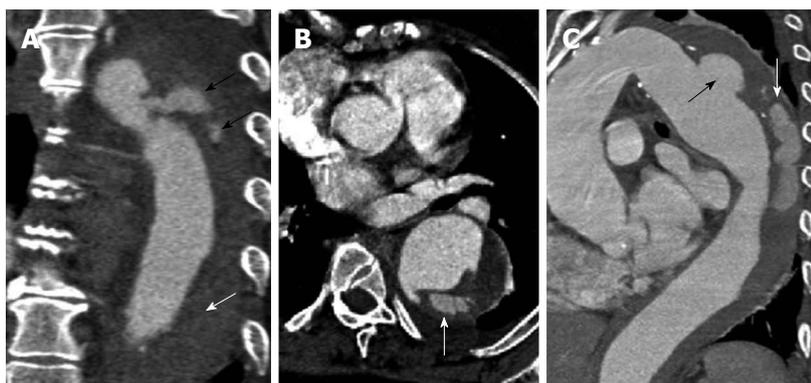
A 62-year-old with acute chest pain. A computed tomography aortogram (A-coronal) shows a penetrating atherosclerotic ulcer at the proximal descending aorta with contrast seen within the aortic media (black arrows) and non-opacifying hyperdensity throughout the rest of the descending thoracic aortic wall compatible with intramural haematoma (white arrow). The axial image (B) shows the contrast extending within the aortic wall and splitting the same. The sagittal oblique reconstruction (C) gives a better demonstration of the penetrating atherosclerotic ulcer at the distal aortic arch (black arrow) with intramural hematoma and progressing into an aortic dissection (white arrow).
